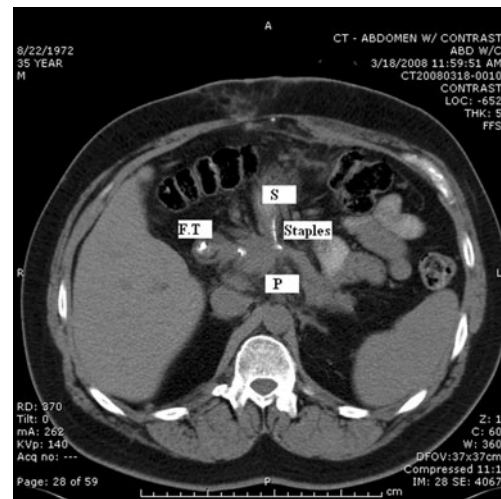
Postoperative CT scan (1 month after the cystogastrostomy): the pancreatic pseudocyst is resolved. The gastric (S) wall shows the staple line of the cystogastrostomy. On the duodenum, a postpyloric feeding tube (FT) is identified.
